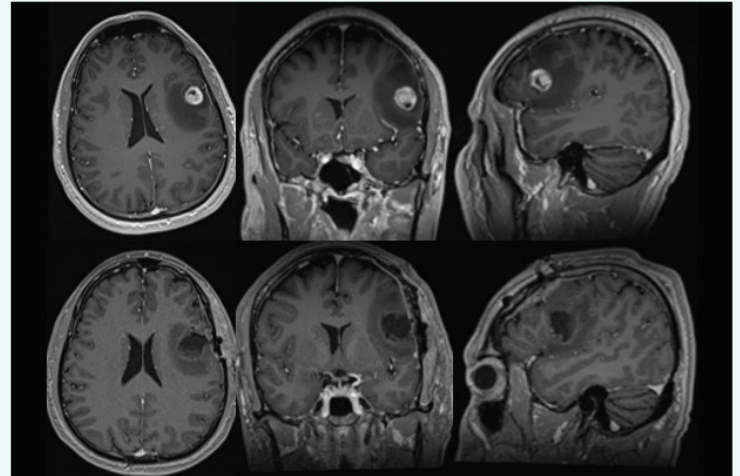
Pre and post-operative contrast-enhanced MRI demonstrating an enhancing lesion within the left frontal lobe with surrounding edema.
